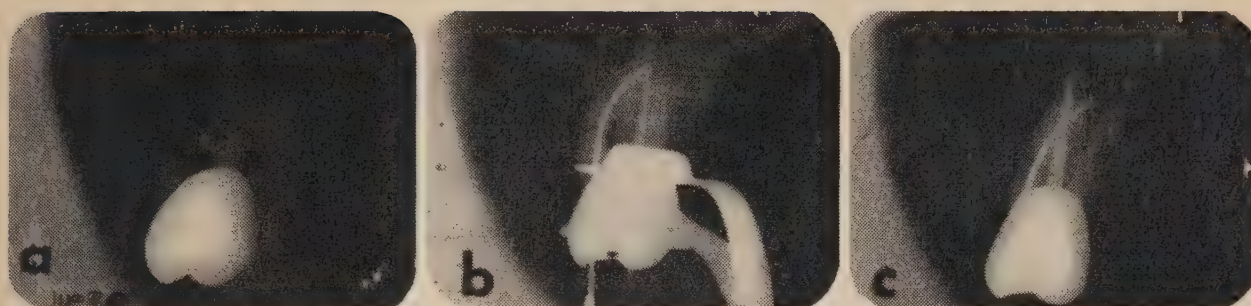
Endodontic treatment of a maxillary first permanent molar. (a) Preoperative radiograph. Chronic rarefying paraendodontitis associated with the lingual root canal. Extremely curved mesial canal with necrotic content. Content of the distal canal is vital. (b) Trying of the cones. Note the vertical access and maximum straightening of the mesial canal. (c) Completed obturations.
